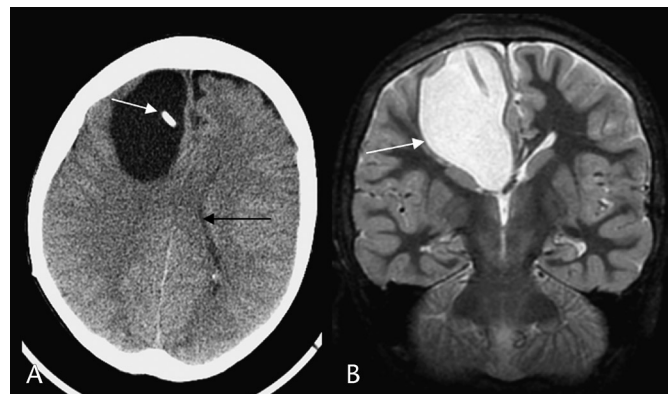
Pericatheter cyst. Noncontrast CT (A) shows a large right frontal low-density cyst along the ventricular catheter (white arrow) and small lateral ventricles (black arrow). Coronal short τ inversion recovery (B) image shows the relationship of the high-intensity pericatheter cyst (white arrow) to the small third and lateral ventricles.
